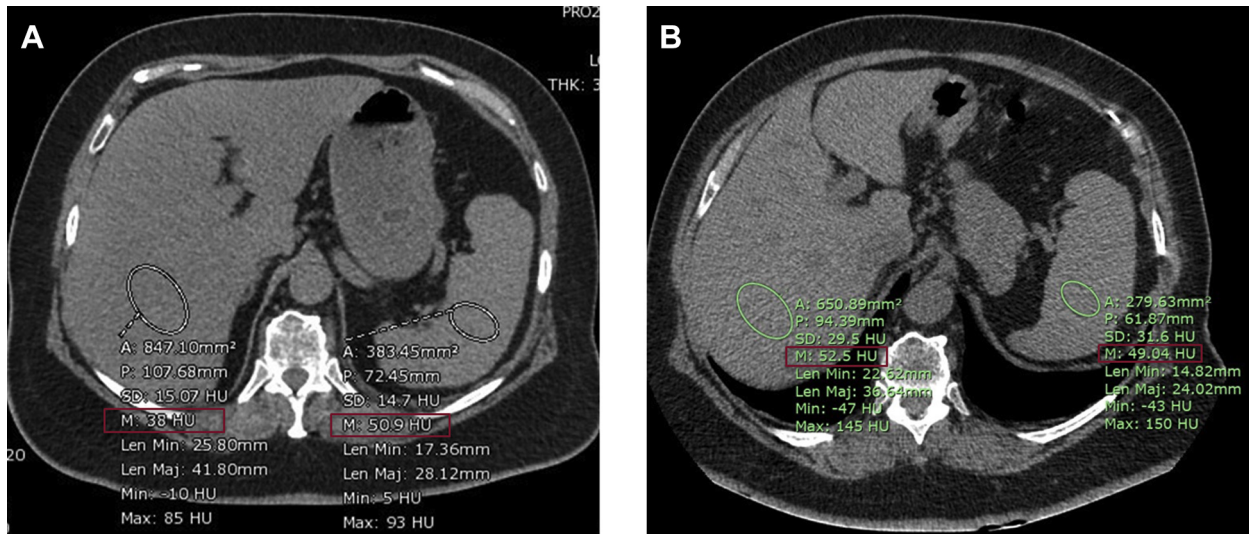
Precontrast computed tomography scans of liver steatosis before (A) and after mifepristone treatment (B). Red boxes show the mean attenuation values calculated from regions of interest (white (A) and green ovals (B) indicate the region of interest). After mifepristone treatment, fatty liver was reversed. A = area; HU = Hounsfield unit; Len Min = length minimum; Len Maj = length major; M = mean; Max = maximum; Min = minimum; P = perimeter; SD = standard deviation.
